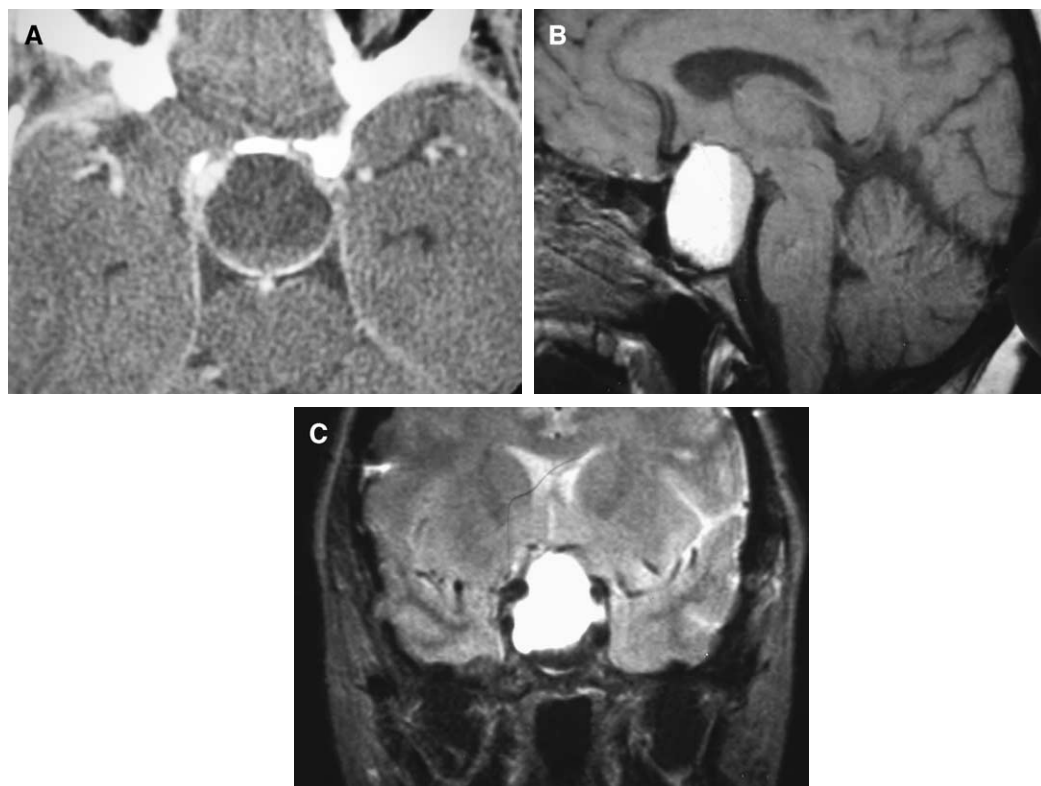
Craniopharyngioma. (A) Axial postcontrast CT scan shows a cystic mass with rim enhancement in the suprasellar region. (B) Sagittal T1-weighted image shows a large cystic mass involving the sellar and suprasellar regions. The mass shows high signal intensity on T1-weighted imaging, consistent with high protein content. A fluid-fluid level is seen within the cystic lesion. (C) Coronal T2-weighted image demonstrates a high signal intensity mass with suprasellar extension and slight parasellar extension into the cavernous sinuses.
